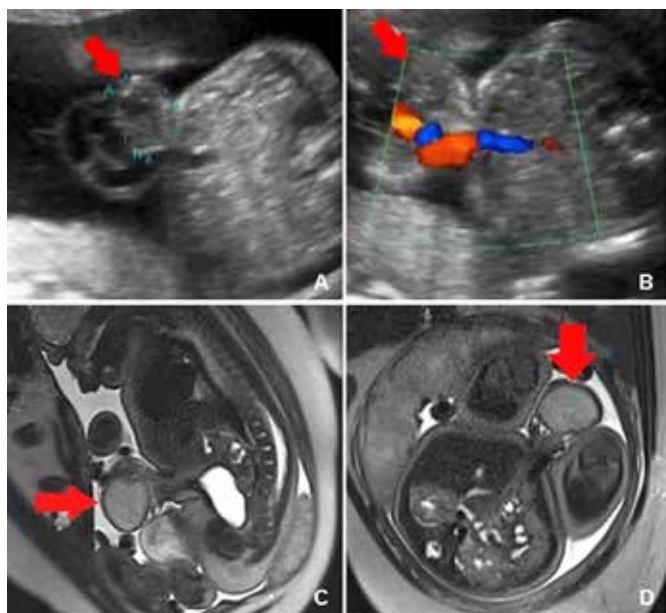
Fetal ultrasound at 21 weeks and 6 days showing the omphalocele with an apparently abnormal circular-shaped image within the umbilical cord (red arrows) (Fig. 1A and 1B). Fetal MRI revealing the omphalocele. There was a hyperintense image inside it, on T1 and T2 sequences, consistent with a Meckel's diverticulum (red arrows) (Fig. 1C and 1D).
